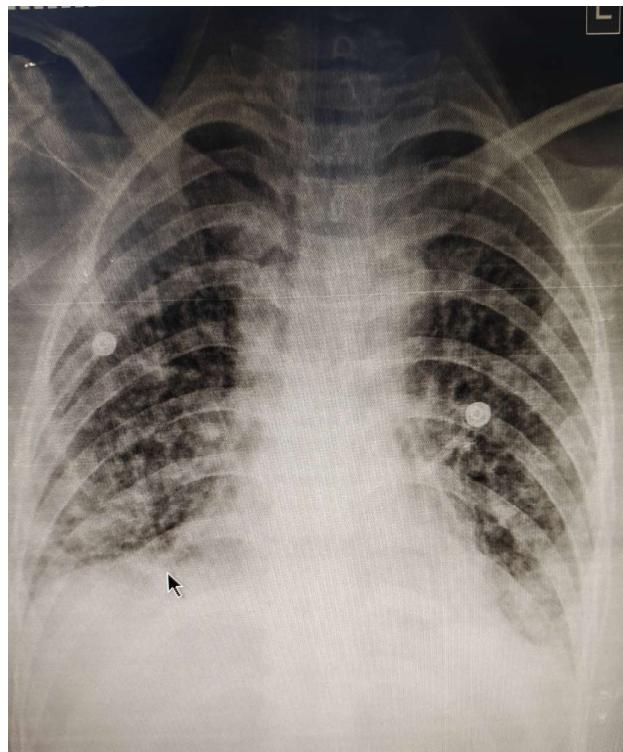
Chest X-ray anteroposterior view showing bilateral heterogeneous opacities predominantly in the lower zones with blunting of the left costophrenic angle.
